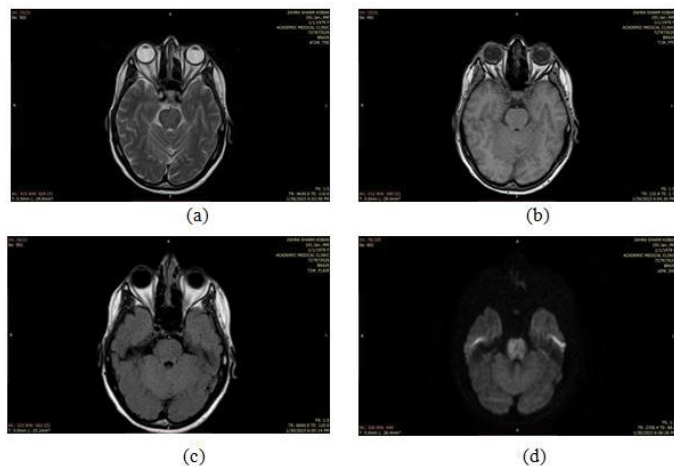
States the hyperacute stroke taken by (a) (T1W) sequence, (b) (T2W) sequence, (c) (FLARE) sequence, (d) (DWI) sequence.
